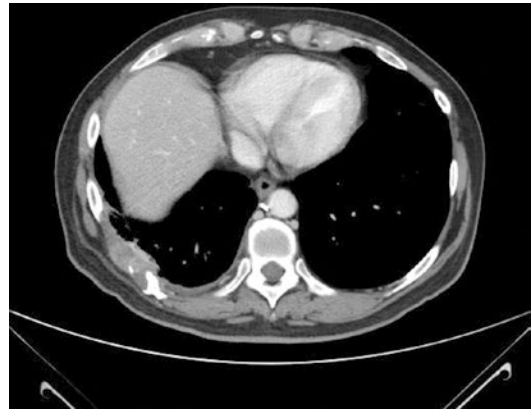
Axial CT section capturing osseous involvement and tumor extension as demonstrated by destruction of the right eighth rib (arrow) with an expansible mass
